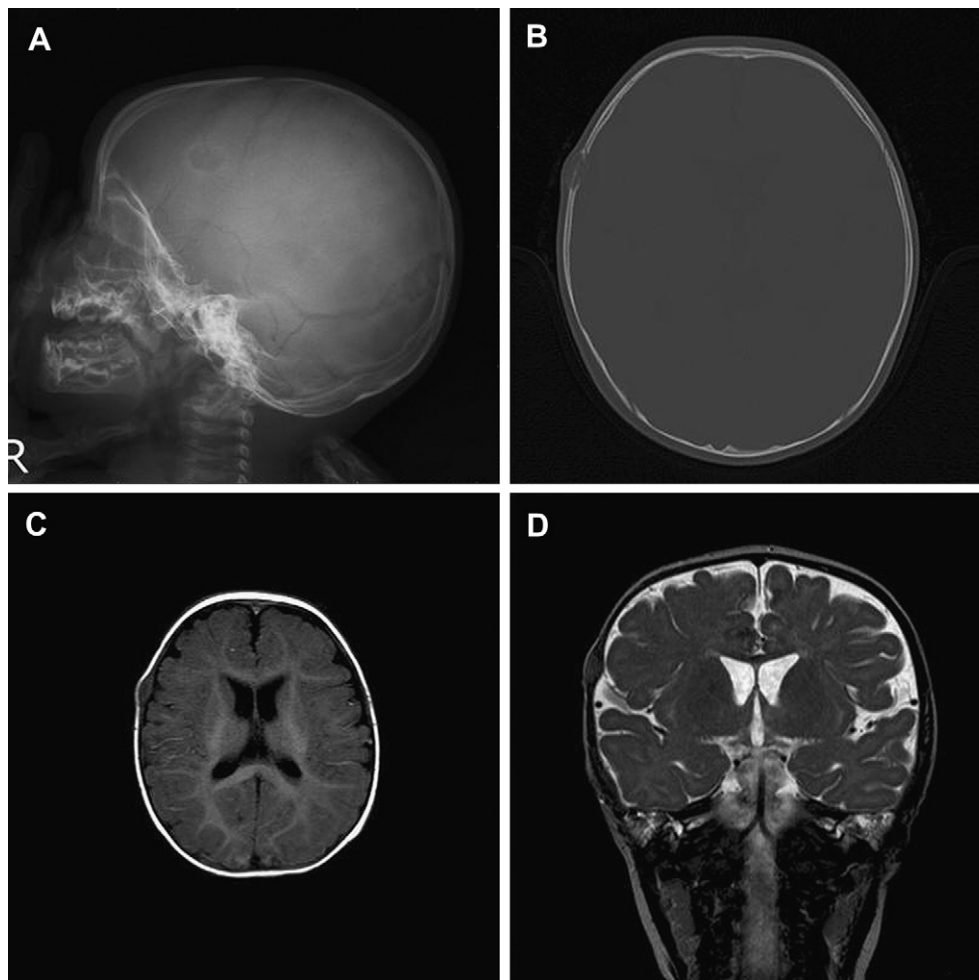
Radiological pictures. (A) Skull X-ray showing a 1-cm ovoid osteolytic lesion with thin sclerotic border in the right frontoparietal region. (B) An unenhanced CT scan of a brain showing a 1 cm osteolytic lesion involving both inner and outer tables with soft tissue component in the right frontoparietal region without intracranial invasion. (C) and (D) Magnetic resonance images demonstrating a lesion with intermediate signal intensity in the right frontoparietal region on T1-, T2- and diffusion-weighted images.
